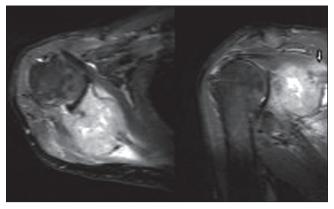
A hyperintense mass lesion located in the infraspinatus muscle and infiltrating the scapula and the supraspinatus muscle is seen on these axial and coronal fat-suppressed T1-weighted images (arrow)
